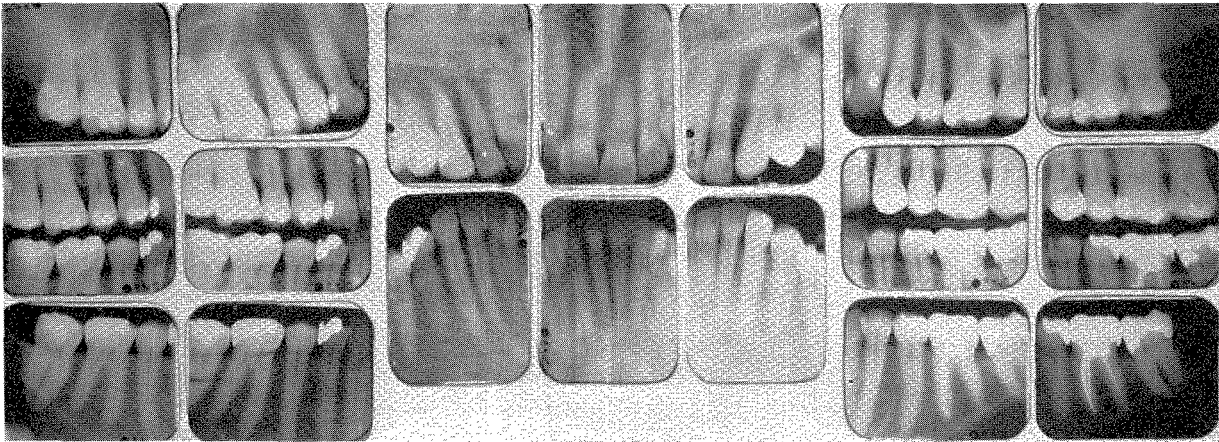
1962 roentgenograms. The patient shown in Figs. 33 and 34. She is now 60 years of age. Excellent oral structures.
